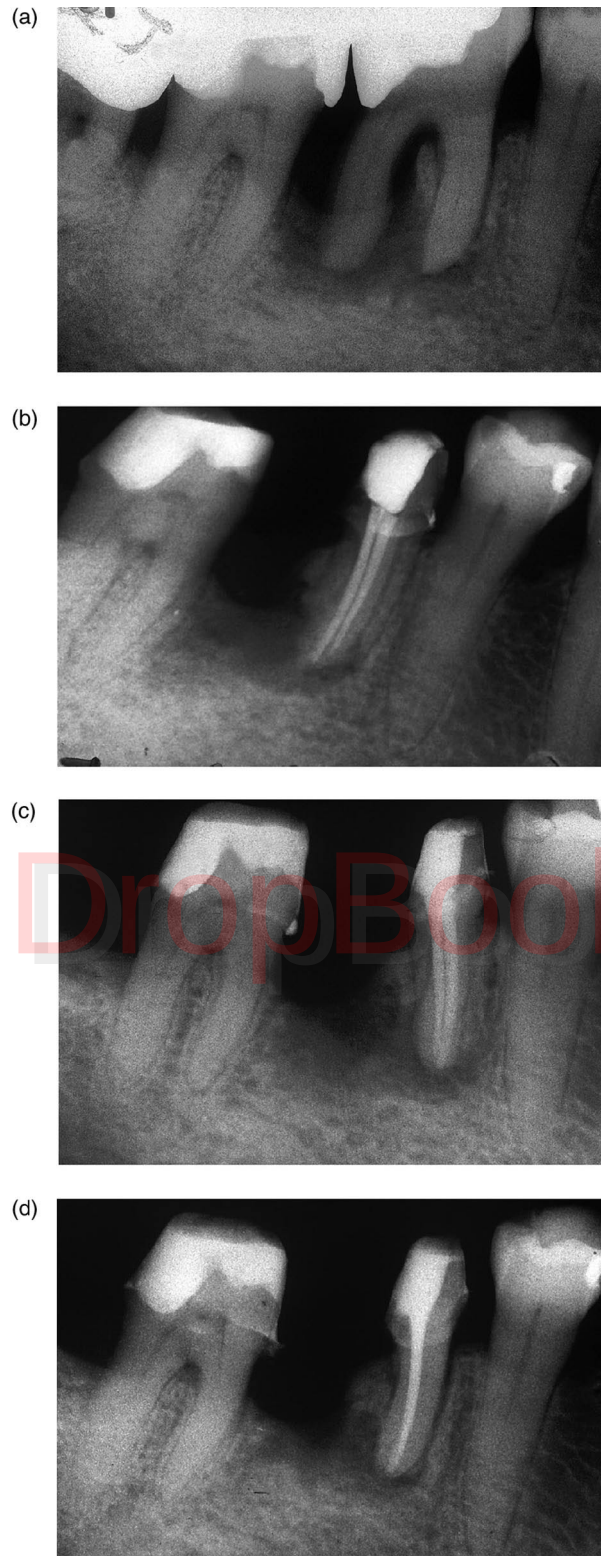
X-ray image of bony defect at tooth 46 in April (a), June (b), December (c) of 2000, and June of 2001 (d).
